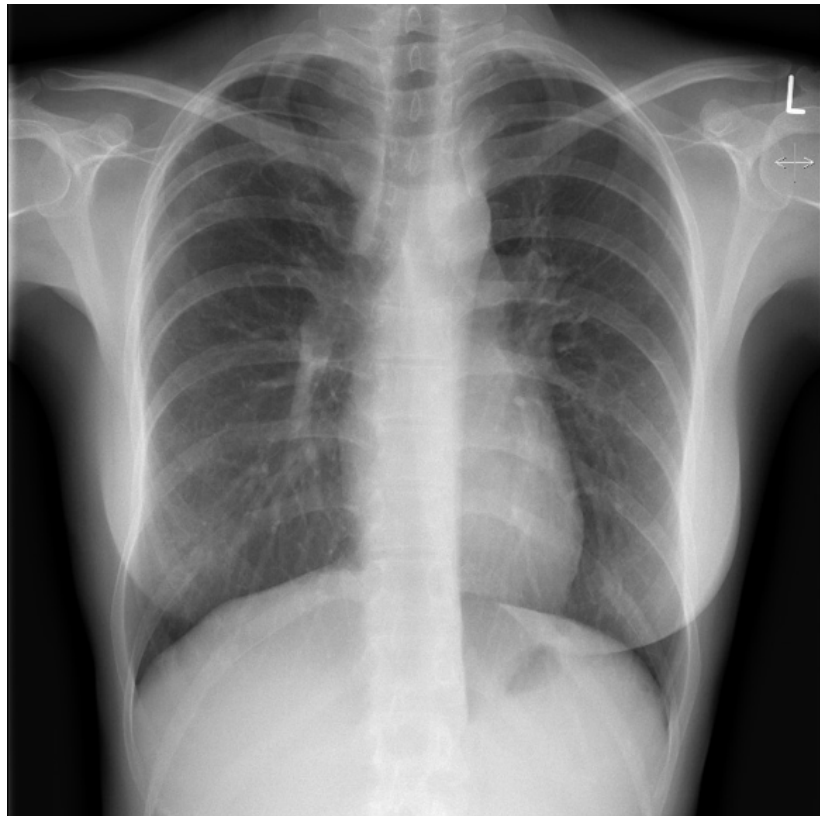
Chest x-ray demonstrating a full radiological resolution following discontinuation of Adalimumab and commencement of oral steroids (9 weeks from initial presentation). L indicates the patient's left side.
